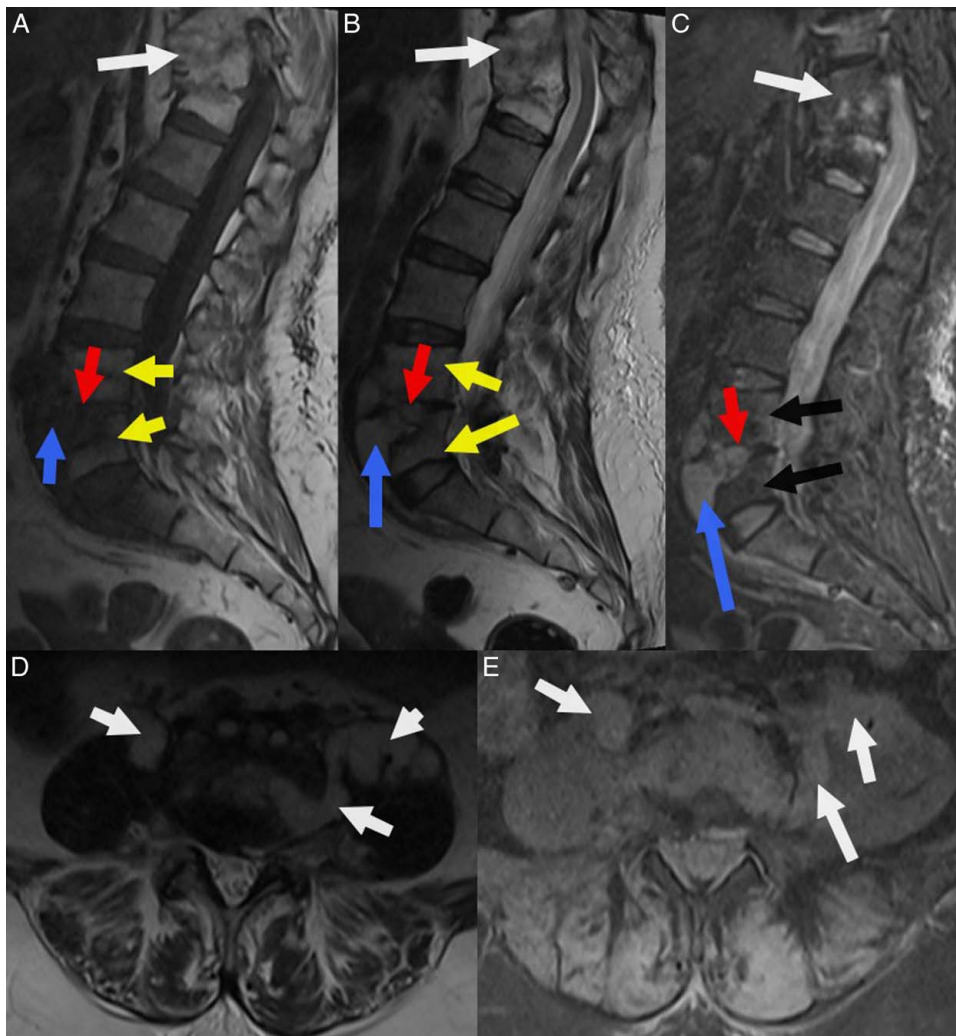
Follow-up spinal MRI in sagittal (A, B, C) and axial (D, E) plane performed 6 months after antibiotic therapy showing: – Sequelae of infectious treated thoracic spondylodiscitis with an almost total fusion of D10, D11, and D12 responsible for thoracolumbar hinge angulation (A, B, C; white arrows) and without any infectious activity signs. – Irregularities and subchondral erosions of the lower vertebral endplate of L4 and upper L5 with signal abnormalities of L4 and L5 vertebral body in hypointense on T1-weighted image (A; yellow arrows) and hypersignal on T2-weighted image (B; yellow arrows) and moderate enhancement after Gadolinium injection (C, black arrow). – Intradiscal abscess (A, B, C; red arrows). – Increase in anterior L4 and L5 epiduritis (A, B, C; blue arrows) coming into contact with both L5 roots and infiltration of the anterior and lateral paravertebral soft parts causing both iliopsoas muscles abscesses (D, E; white arrows).
